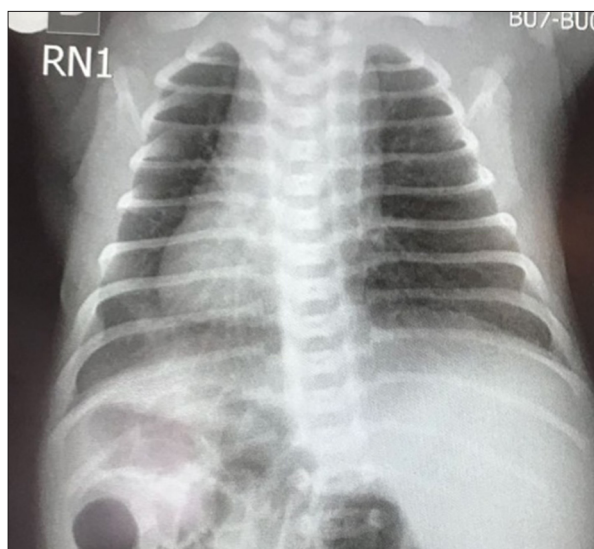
X-ray after respiratory distress and installation of bubble CPAP.
